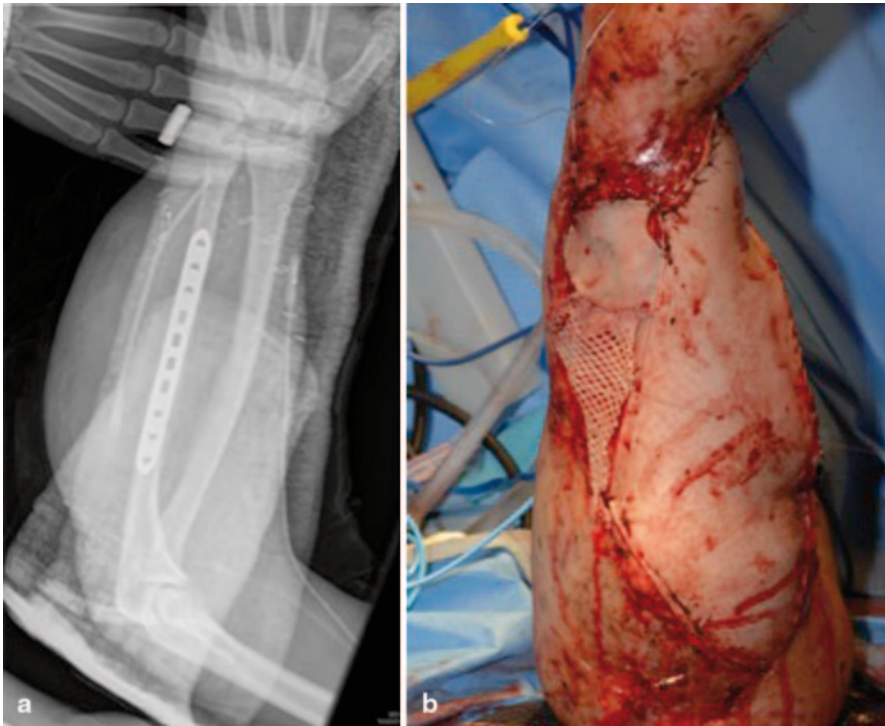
After initial injury and battlefield tourniquet placement to his right upper and bilateral lower extremities, the patient was medically evacuated to the Role 3 medical facilities in Kandahar, Afghanistan, where an initial irrigation and debridement was performed on his right upper extremity. His forearm wound was packed and a splint was applied. The following day, the patient was transferred to the Role 4 medical facility at Landstuhl Regional Medical Center in Germany, where a second irrigation and debridement was performed and negative pressure wound therapy was started on his forearm. On 10 April, the patient was evacuated to the Role 5 medical facility in Bethesda, MD. He underwent subsequent irrigation and debridements to manage his wound until it was ready for his definitive procedure. Three and a half weeks after initial injury, he underwent open reduction and internal fixation of the ulna, with allograft bone grafting to address the bone defect, and anterolateral thigh free tissue transfer with microvascular anastomosis to the left forearm. The x-ray image (a) demonstrating his definitive fixation and a clinical photograph (b) of his definitive soft tissue coverage procedure are shown
